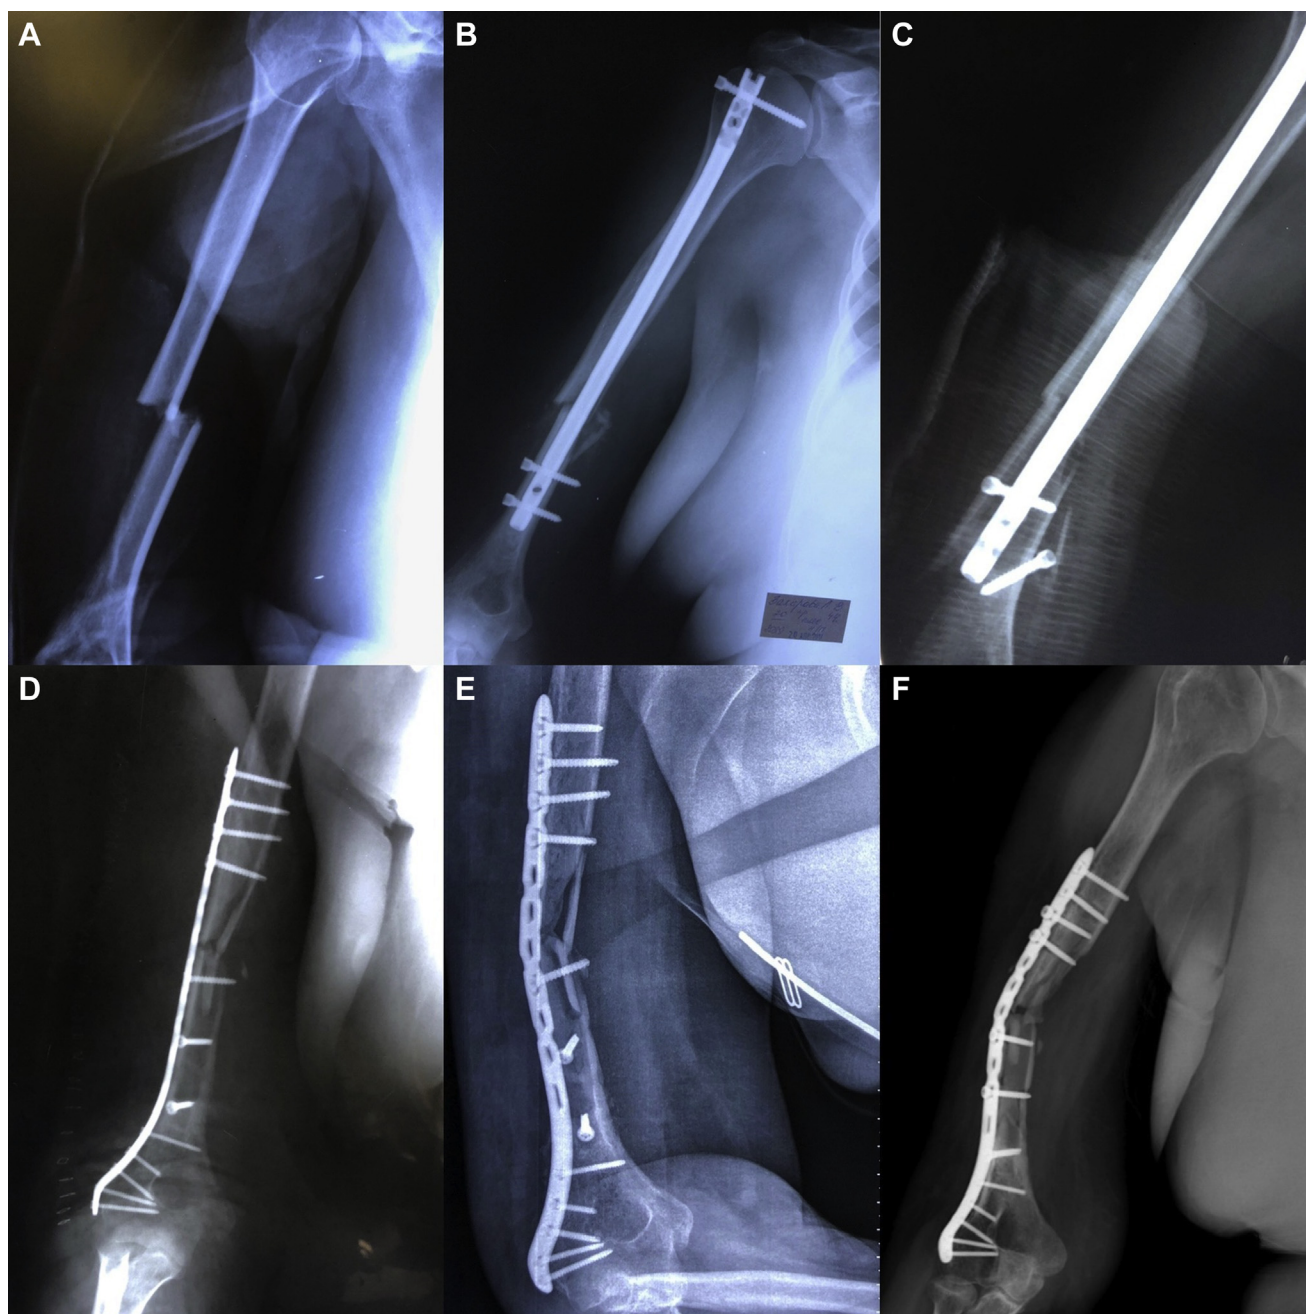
(A and B) AO/OTA 12-A3 fracture treated with intramedullary nailing; (C) peri-implant fracture after 4 months; (D) post-operative films after nail removal and plate fixation; (E and F) follow-up radiographs after 4 and 8 months. AO/OTA, AO Foundation/Orthopaedic Trauma Association classification.
